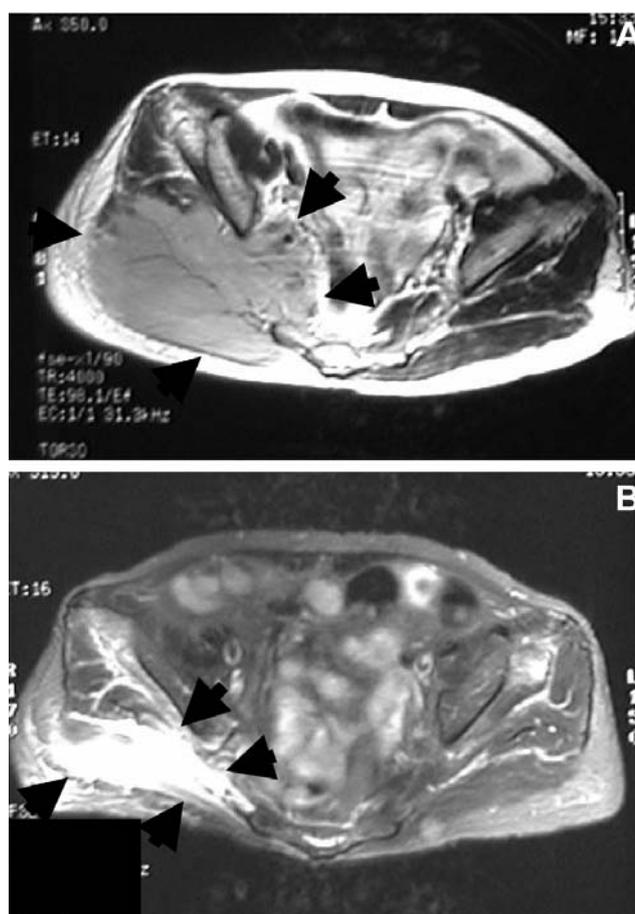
MRI findings before and after chemotherapy. A. Large soft tissue tumor is found in the right buttock. B. The tumor mass disappeared after one course of chemotherapy. Arrows indicate the soft tissue tumor.
